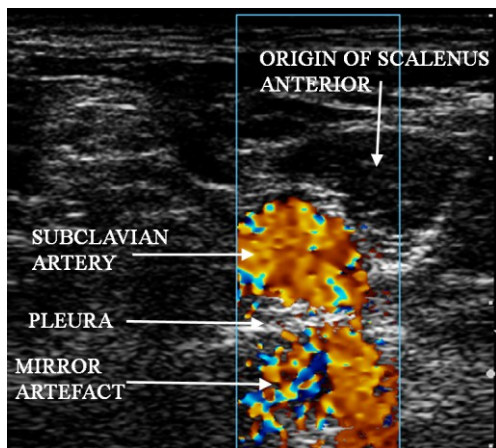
Sonogram of the origine of scalenus anterior identified by the position of the subclavian artery. Note the mirror artefact caused by the strongly reflecting pleura.
